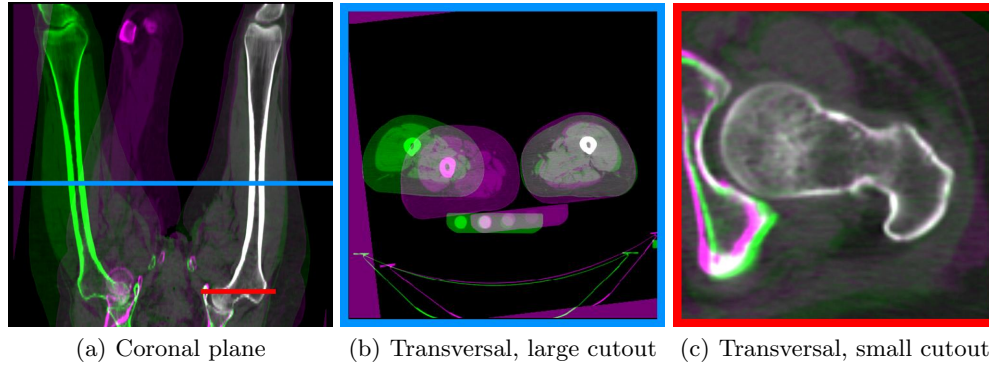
Overlay images of two CT volumes, registered at the right femur. The lines in the (a) image show the location of the transversal slices at the upper line (b) and the lower line (c).
